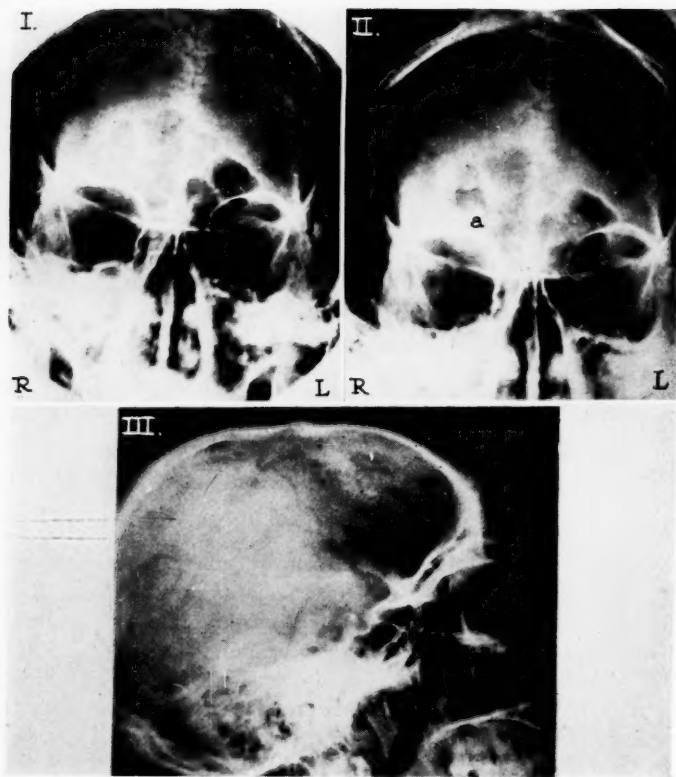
X-ray films of the frontal sinuses in Case 5. Film I was taken on July 25, 1941. Note the thickening of the floor of the right frontal sinus.
